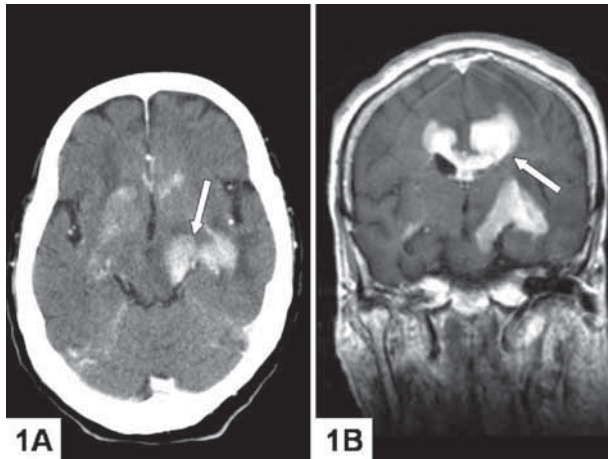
Cranial contrast-enhanced CT (1A) and T1-weighted MRI (1B) demonstrated an irregular tumor mass (arrows) in cross and longitudinal sections respectively which displaying butterfly-shaped pattern with involving the pericallosal region, posterior periventricular white matter, orbitofrontal lobes, right basal ganglion, left temporal lobe, thalamus, cerebral peduncle of midbrain and the left lateral pons with profound perifocal edema.
